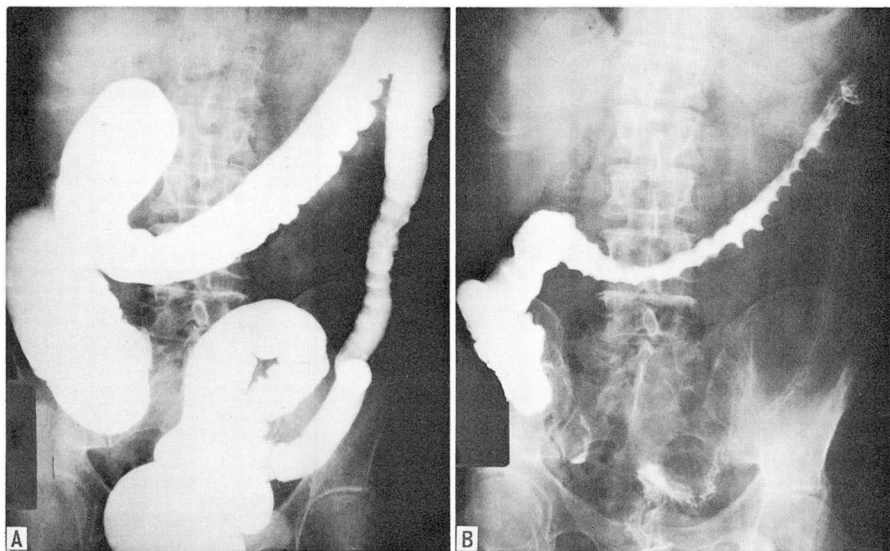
Case 1 (6-10-58). A, Roentgenogram after barium enema, showing a return of haustral markings and a return of the colon to normal. B, Progress evacuation roentgenogram that also shows improvement.
